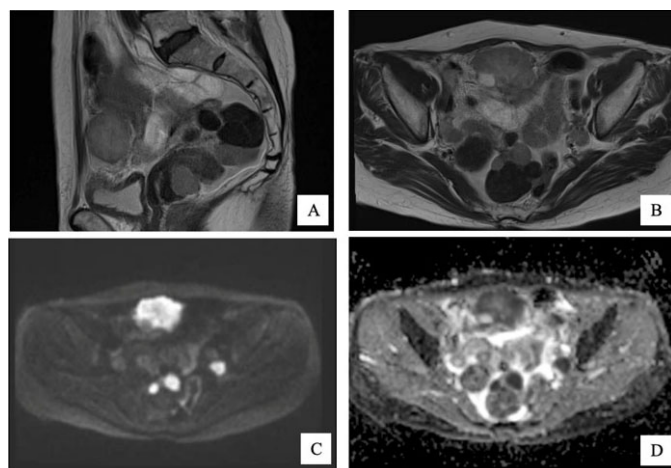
Pelvic magnetic resonance imaging findings. (A) Sagittal T2-weighted image (T2WI) showing a well-circumscribed uterine mass with heterogeneous internal signal intensity. (B) Axial T2-weighted image (T2WI): multiple uterine lesions predominantly showing low signal intensity suggestive of leiomyoma. (C) Axial diffusion-weighted image (DWI, b = 1000 s/mm²): A high-signal area was detected around the uterine leiomyoma, suggesting peritoneal dissemination. (D) Apparent diffusion coefficient (ADC) map: The corresponding area shows low signal intensity, supporting diffusion restriction.
